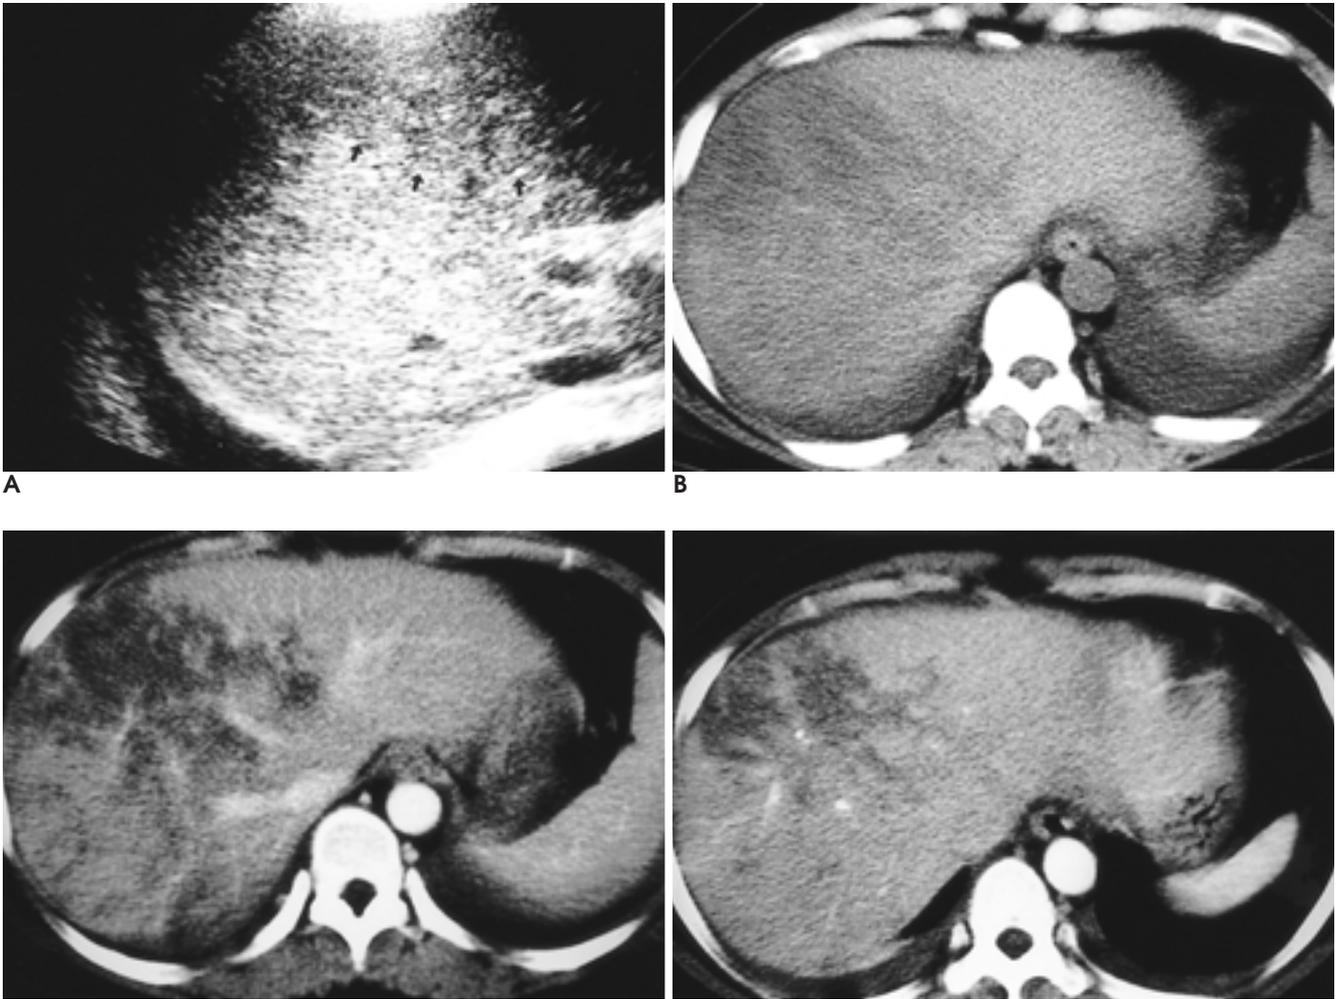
A. Transverse US scan performed on postpartum second day demonstrates geographic hypoechoic areas with poorly defined margin in peripheral portion of right hepatic lobe (arrows). B. Precontrast CT of the liver shows geographic areas of low attenuation mainly in right hepatic lobe. C. Contrast enhanced scan demonstrates nonenhancing well-defined, mottled appearing wedge shaped area. Enhanced vessels are seen coursing through these lesions. D. Ten days later, follow up CT scan shows more discrete margin and decreased size of the hepatic lesions.
